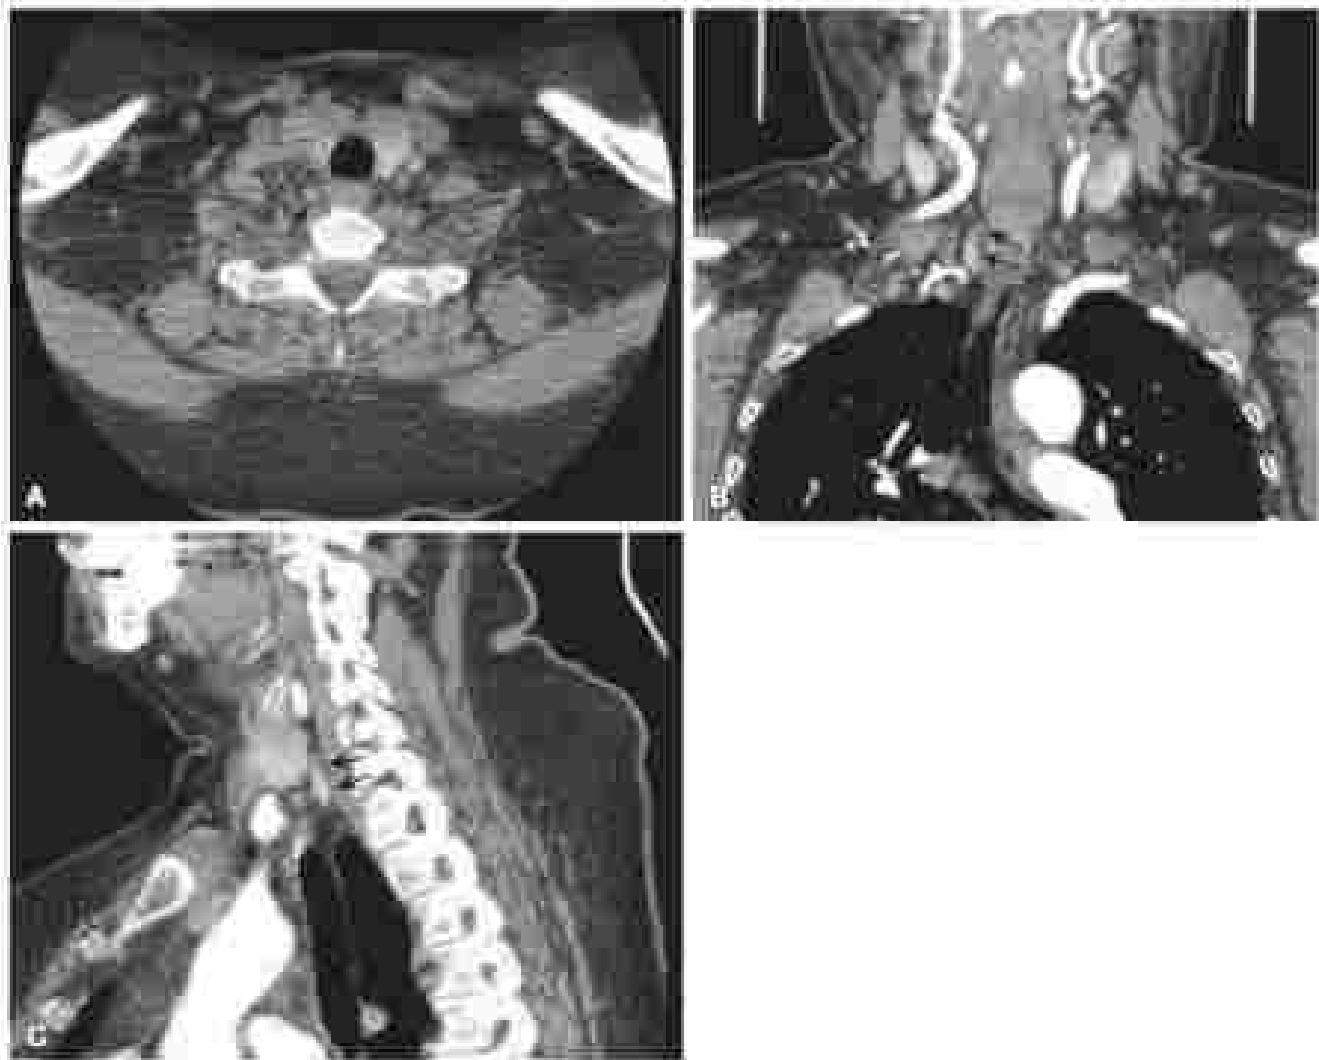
Four-dimensional computed tomography scan with (A) axial, (B) coronal, and (C) sagittal sections taken during the surgical phase of an enlarged right inferior parathyroid adenoma.
